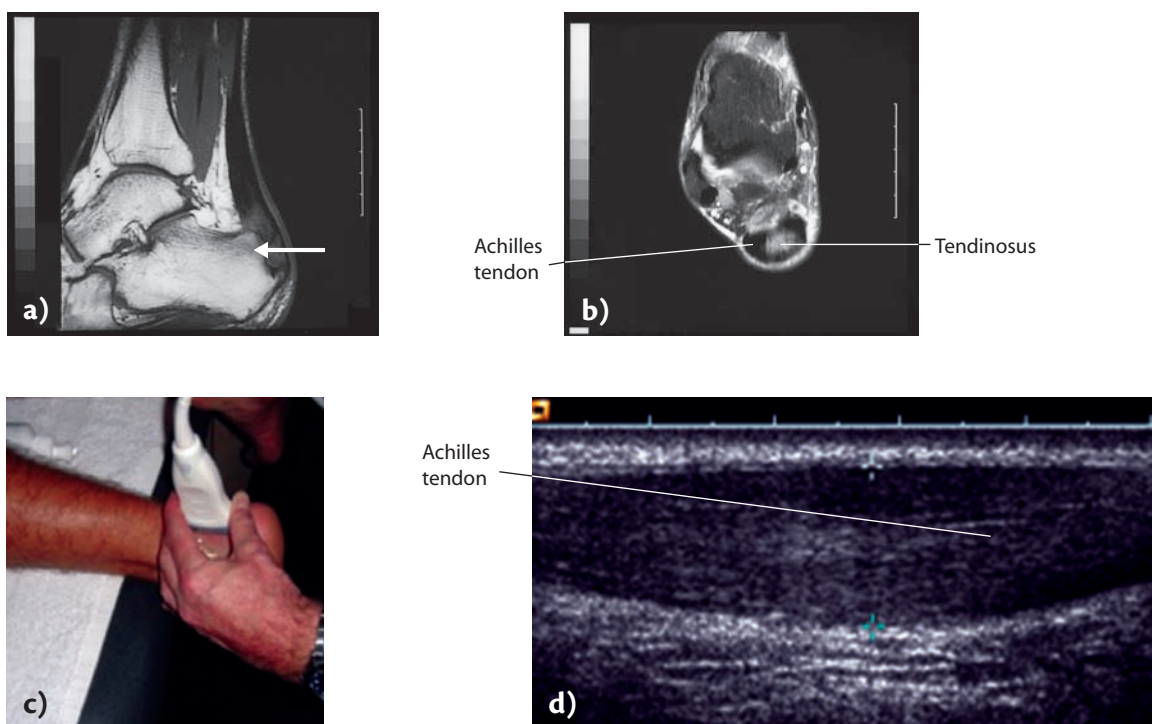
Magnetic resonance imaging (MRI) or ultrasound of Achilles tendinopathy (tendinosis). a) MRI show changes in the distal Achilles tendon. The arrow shows a bony enlargement on the top back of the heel bone (calcaneus) ('Haglund deformity'); b) MRI showing a cross-section of the Achilles tendon with clear degenerative changes shown by the arrow; c) ultrasound examination of the Achilles tendon; d) Achilles tendon during an ultrasound examination. The picture shows a normal Achilles tendon depicted by an arrow.
